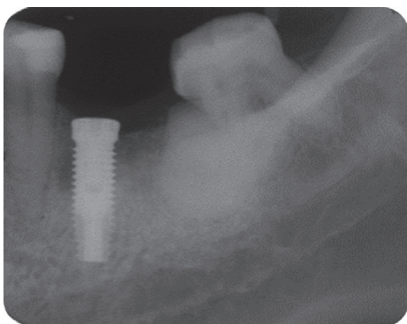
Periapical radiograph of the time when implant was placed four months after the extraction.
